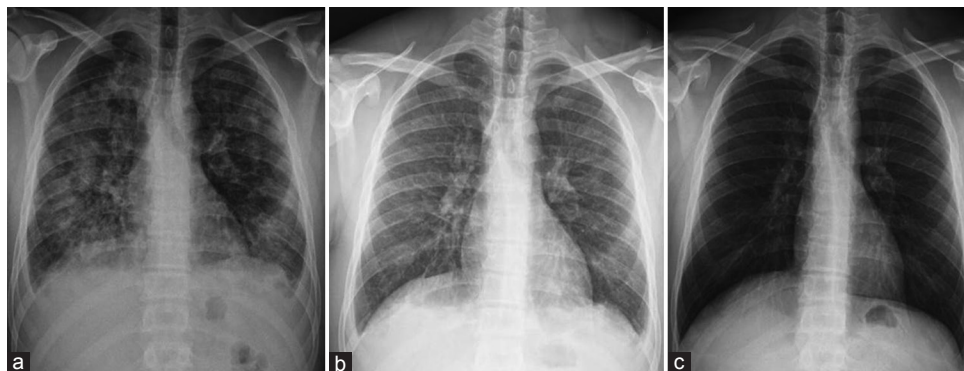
(a) Admission chest X-ray showed bilateral pulmonary infiltrates with bilateral blunted costodiaphragmatic angle. (b) The parenchymal infiltration except bilateral mild pleural effusion was almost resolved radiographically following 2 days of corticosteroid treatment. (c) Completely resolved chest X-ray after 2 weeks of treatment
